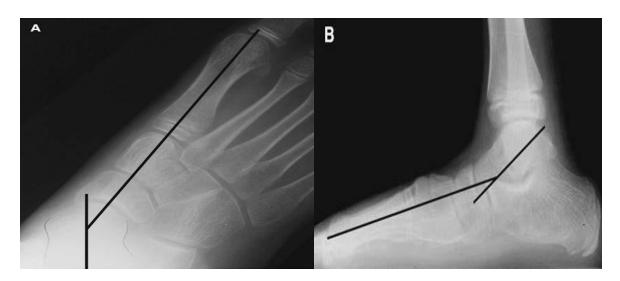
Standing radiographs of a flatfoot showing talus and first metatarsal axis lines crossing at the center of rotation of angulation (CORA) in the center of the head of the talus, indicating a single deformity at the talo-navicular joint. (A) Anteroposterior view, (b) Lateral view ⁽¹³⁾.
